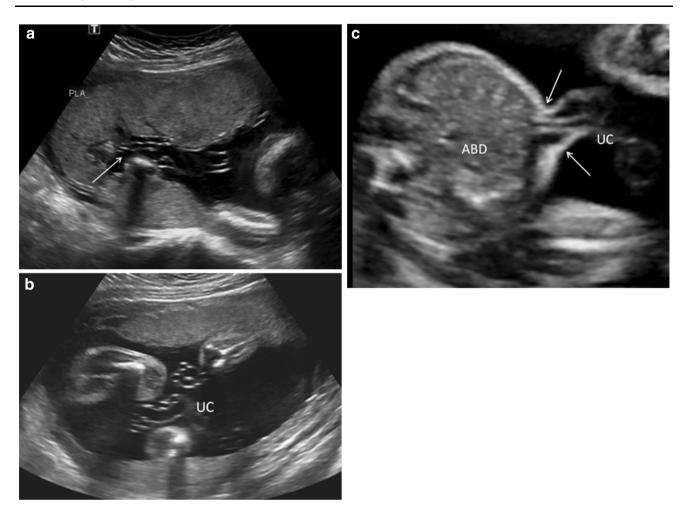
a Sonogram of normal insertion of the umbilical cord into the anterior placenta. b Sonogram of free loop of umbilical cord. c Sonogram of umbilical cord entry into the fetal abdomen. UC umbilical cord, ABD abdomen
